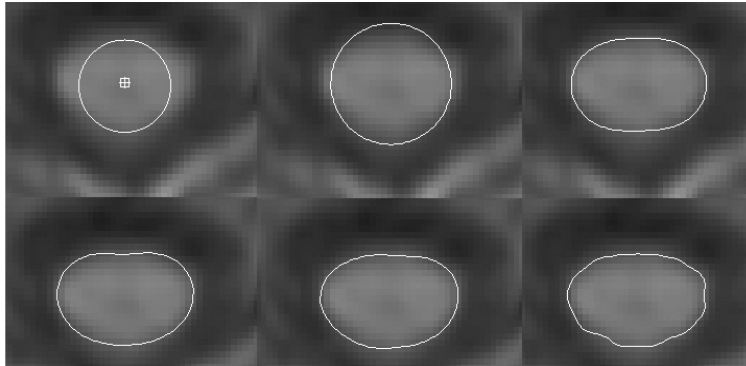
Evolution of the surface at the C2/C3 level for a T1-weighted cord image.
